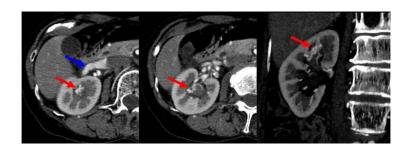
Axial and coronal contrast-enhanced computed tomography images obtained during the early arterial phase show a single tortuous and dilated vessel in the right renal sinus (red arrow) and early filling of the right renal vein (blue arrow).
